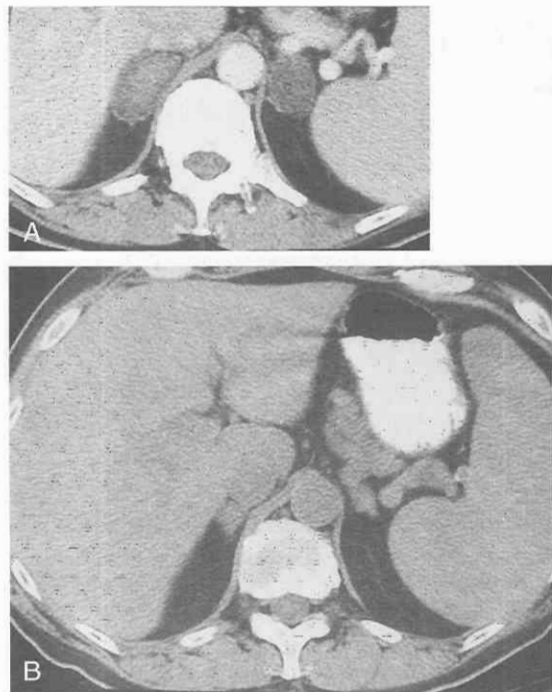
Adrenal masses. *A*, Contrast-enhanced CT scan of the abdomen indicates bilateral adrenal masses that contain high-density material compatible with adrenal hemorrhage. *B*, Follow-up scan performed 7 months later reveals regression of the bilateral adrenal masses, which is compatible with resolution of adrenal hemorrhage.
